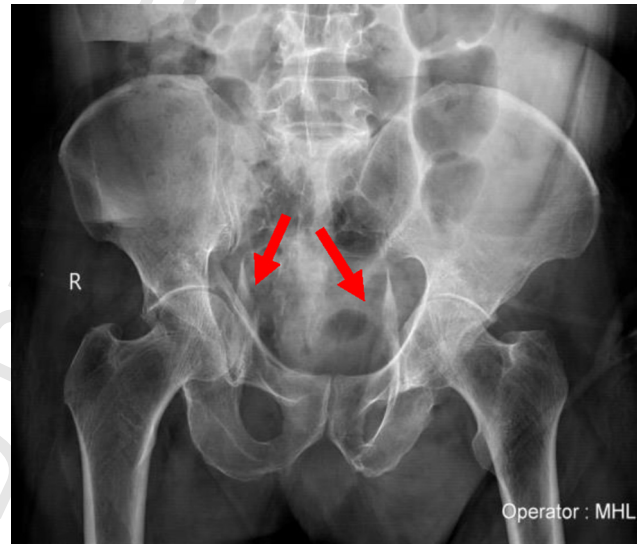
X-ray showing bilateral quadrilateral plate fracture.
